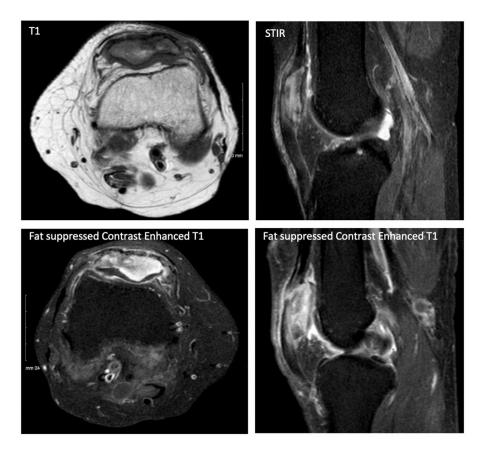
MRI of the left patella revealing marrow replacement of the patella by an aggressive lesion featuring decreased T1 signal, increased STIR signal and avid postcontrast enhancement. There is cortical disruption anteriorly with surrounding soft tissue edema and enhancement of distal quadriceps and proximal patellar tendons.
